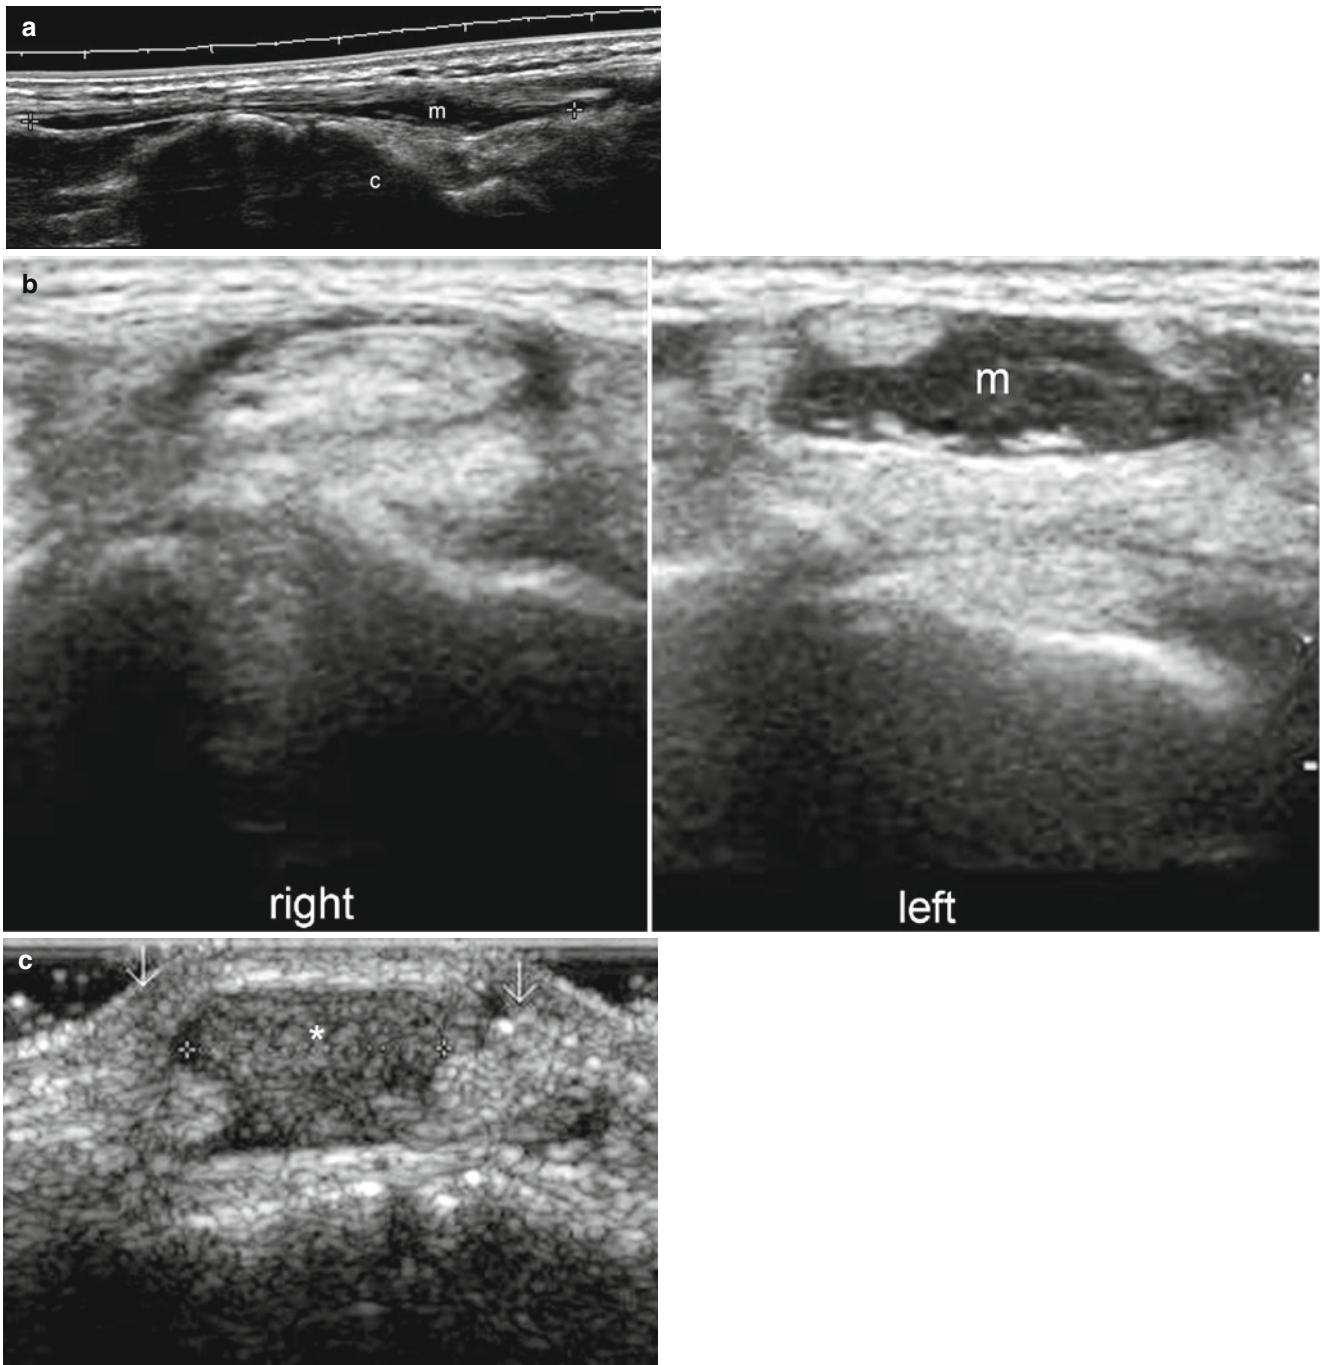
(a–c) Accessory muscle extensor digitorum brevis manus. (a–c) Grey scale ultrasound images in different patients (a longitudinal view of the dorsal aspect of the right wrist and hand; b comparative side by side transverse view of the dorsal wrist; c transverse view dorsal aspect of the left wrist under contraction) show hypoechoic structure
